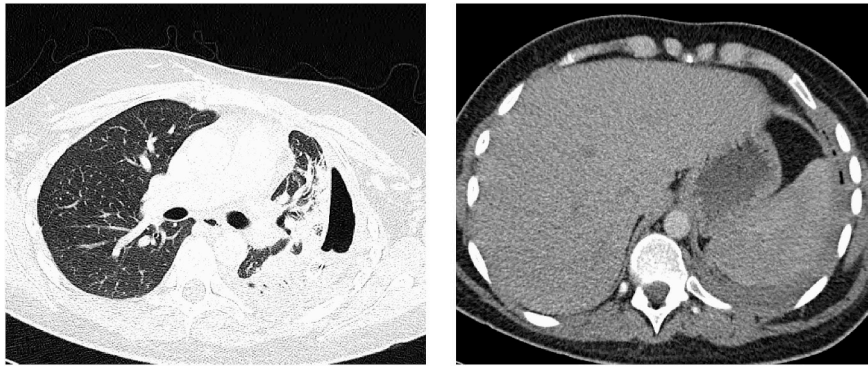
CT thorax on day 14 showing persistent pleural effusion containing multiple locules of air. Lung not fully expanded.
